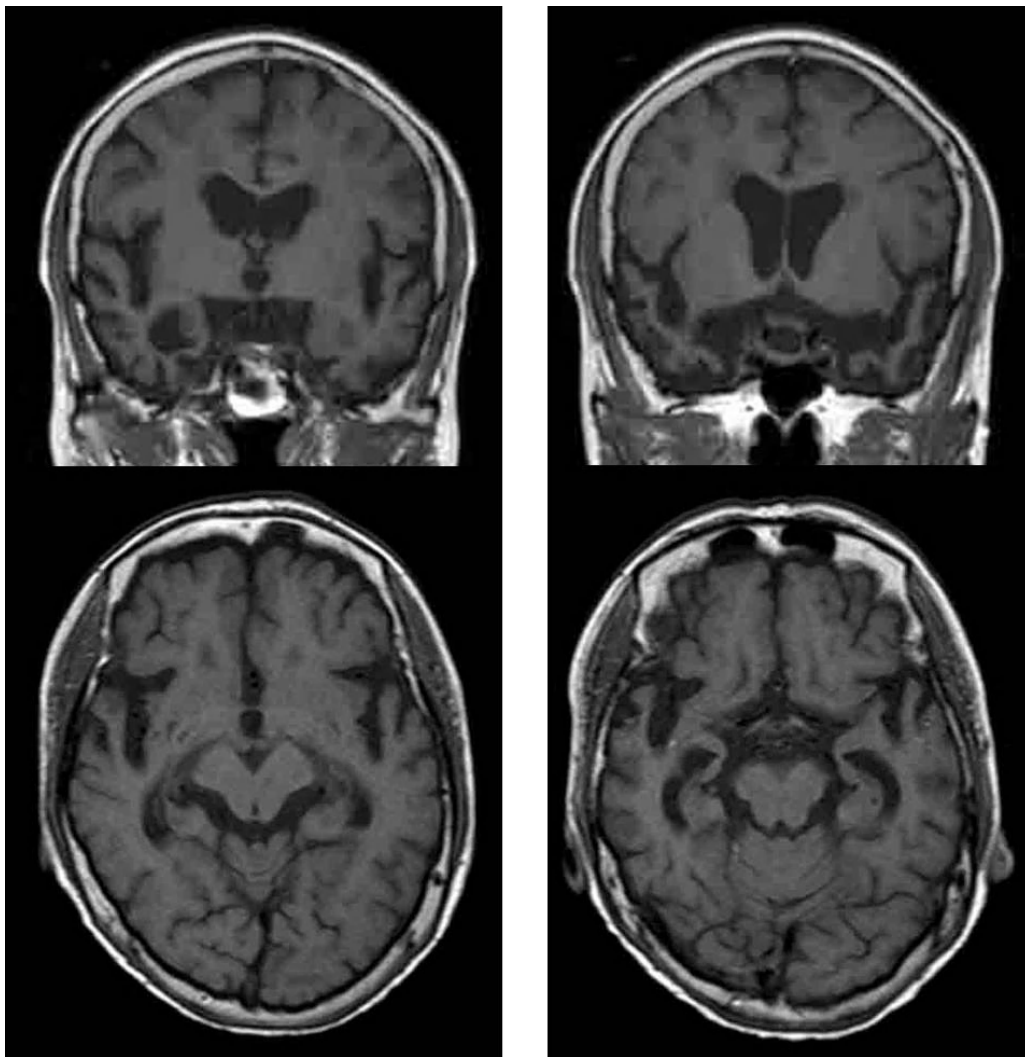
Brain MRI images
